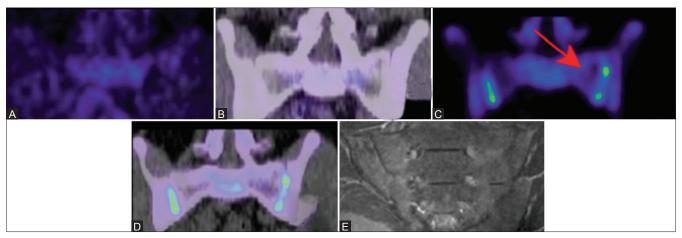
(A-E): Young male patient suspected of sacroillitis undergoing PET studies (A and B) by using (18F) D-glucose and (18F) fluoride radionuclides (C and D) and MRI (STIR) (E) MRI shows no bone edema and (18F) FDG-PET shows no uptake, while (18F) fluoride-PET scan xamination shows hot spot corresponding to osteoblastic bone remodeling. BioMed Central, Fischer DR, et al.[3]
